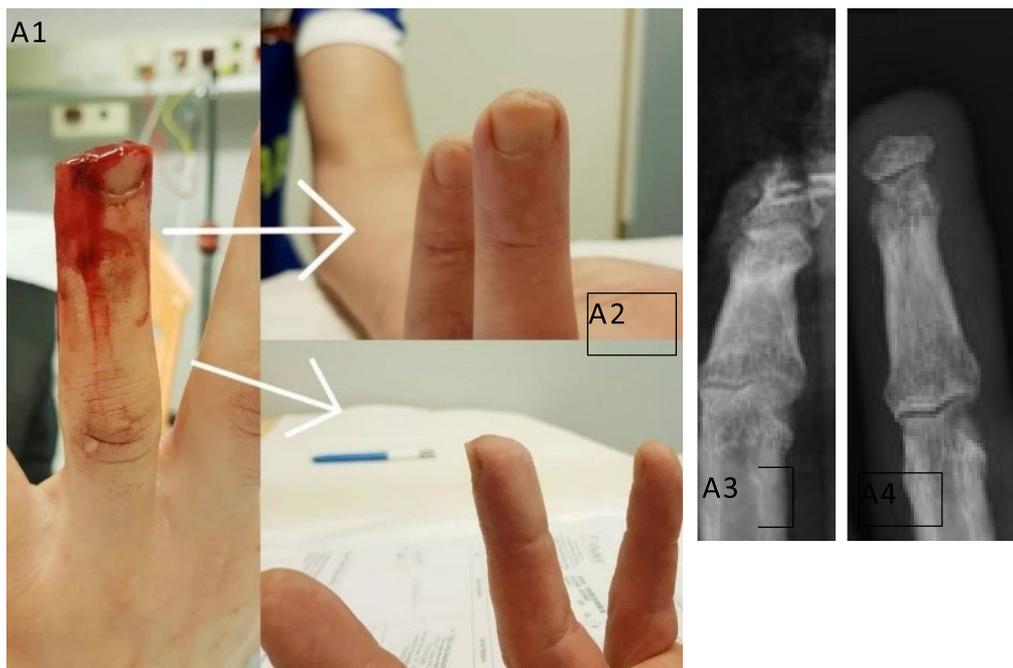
Clinical outcomes of two patients with zone 2 amputations using occlusive dressings. Patient A was a 22-year-old male who had a domestic accident with a cutting machine at the time of the injury (A1). It took three dressings and 17 days for the healing process (A2). Preoperative and postoperative X-rays were taken (A3 and A4).
